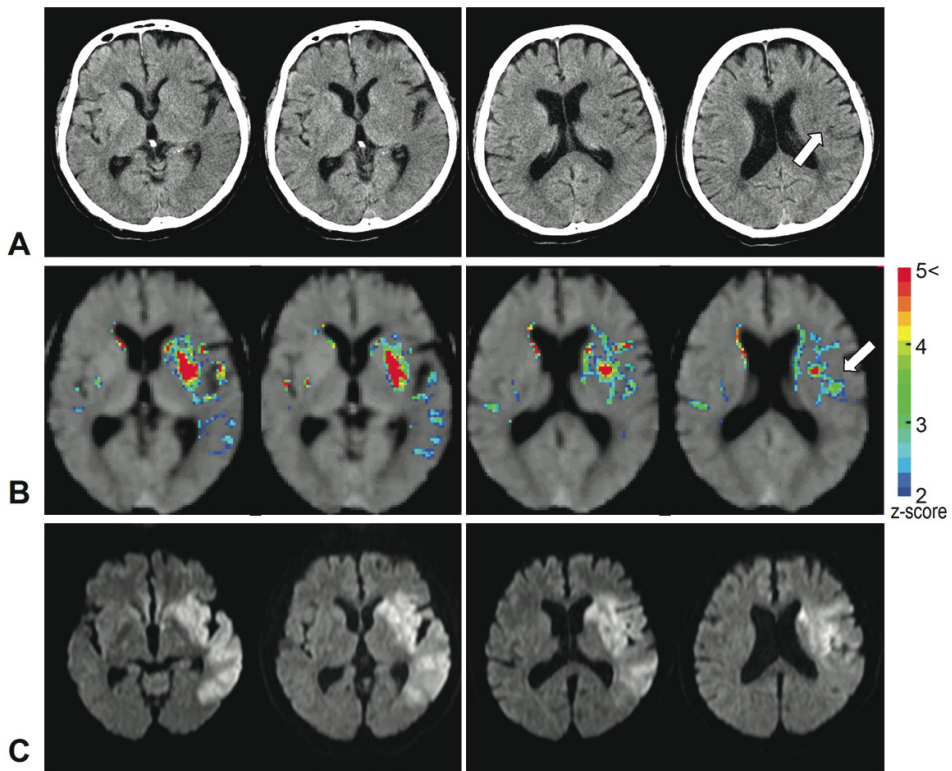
62-year-old-man with the right hemiplegia at 3 hours after stroke onset. (A) Unenhanced CT images show that parenchymal hypoattenuation at the left lentiform nucleus, caudate nucleus, temporal lobe, inferior parietal and posterior temporal lobe, and, precentral and superior frontal lobe (an arrow). (B) Z-score maps prevented three observers from missed identification of hypoattenuation at precentral and superior frontal lobe (an arrow); z-scores are indicated by a color bar (right). (C) Diffusion-weighted MR images taken after the first CT scan reveal hyperintense areas in the left MCA distribution.
